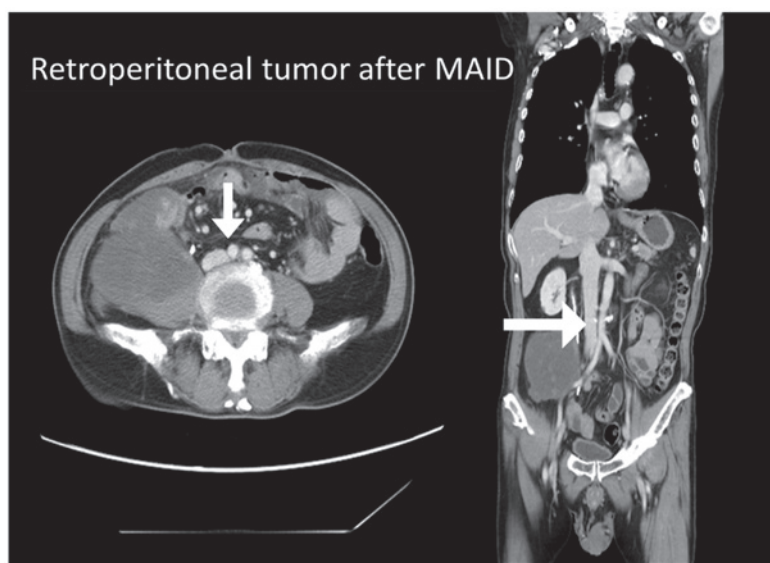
Abdominal scan following MAID treatment. The mass was decreased in size and had reduced levels of necrosis compared with the previous CT scan. White arrows indicate the inferior vena cava. CT, computed tomography; MAID, mesna, tetrahydropyranil adriamycin, ifosfamide and dacarbazine.
